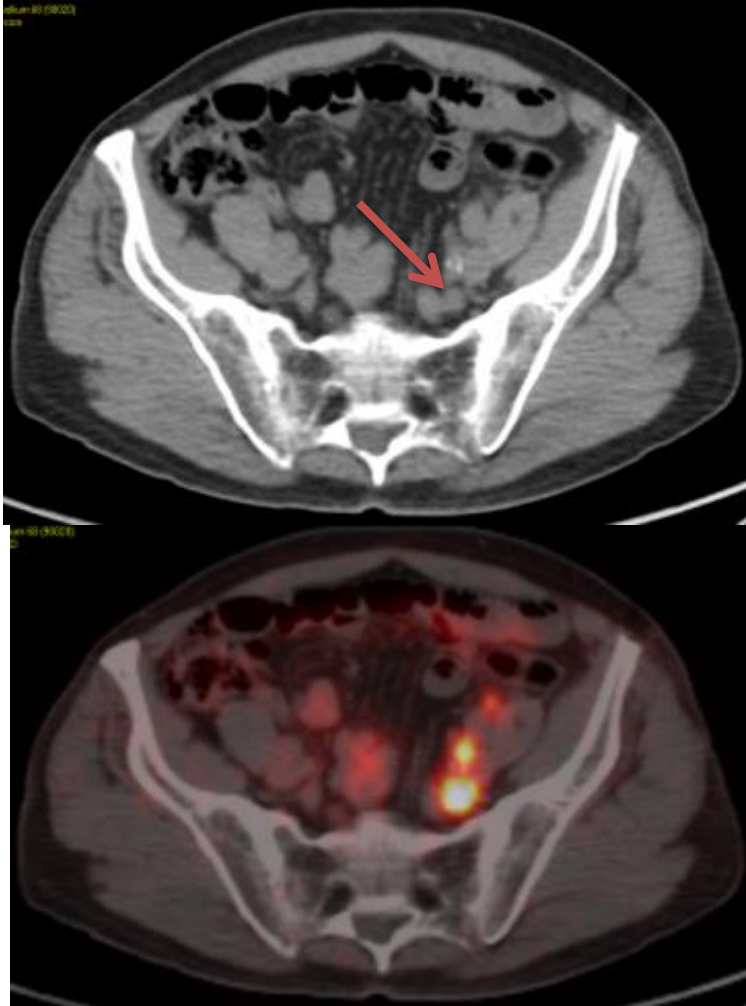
CT and PSMA PET imaging of a man with high risk prostate cancer. CT imaging showed a lymph node in the left common iliac chain which was borderline by size criteria. PSMA shows obvious avidity in this lesion, as well as two much smaller lymph nodes in close proximity. PSMA PET also showed much more widespread nodal disease throughout the pelvis, abdomen and chest, all of which appeared normal on CT imaging.
